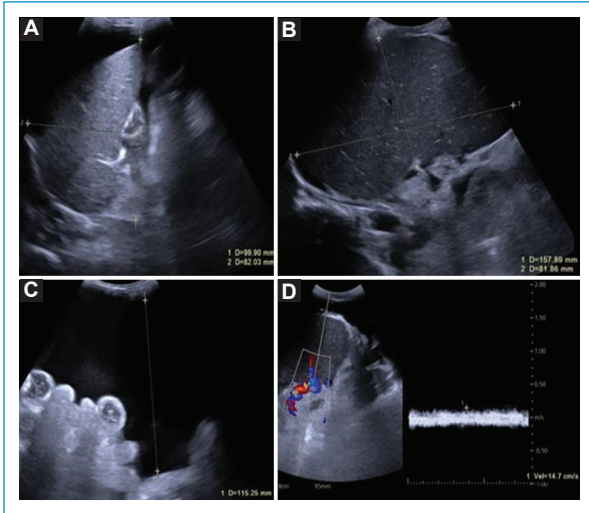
Ultrasound showing normal dimensions of the liver (9cm) with heterogeneous texture (A), splenomegaly (B), and ascites (C), associated with decreased main portal vein peak systolic velocity (D).
